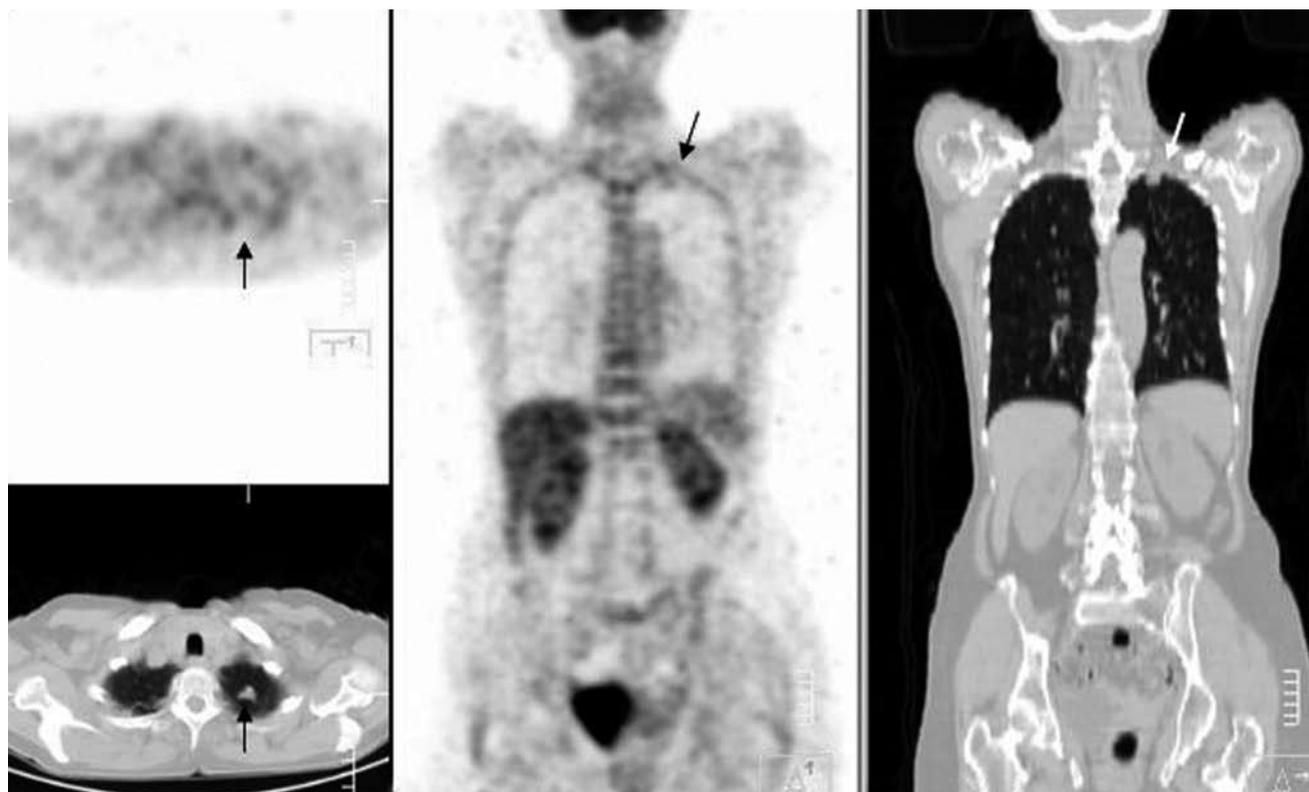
A non-FDG avid solitary nodule in the upper left lung (long arrow) in a 28-year-old male patient. No difference was noted in size in repetitive CT scans with an interval of more than a year. Invasive procedures such as transthoracic biopsy and wedge-resection are not justified in such lesions as the negative predictive value of PET is high and the etiology is almost always benign.
